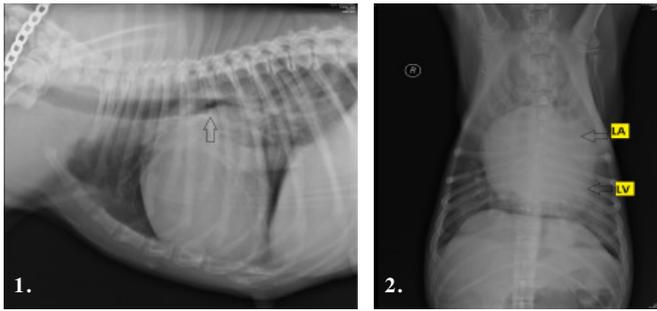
Lateral chest radiograph
